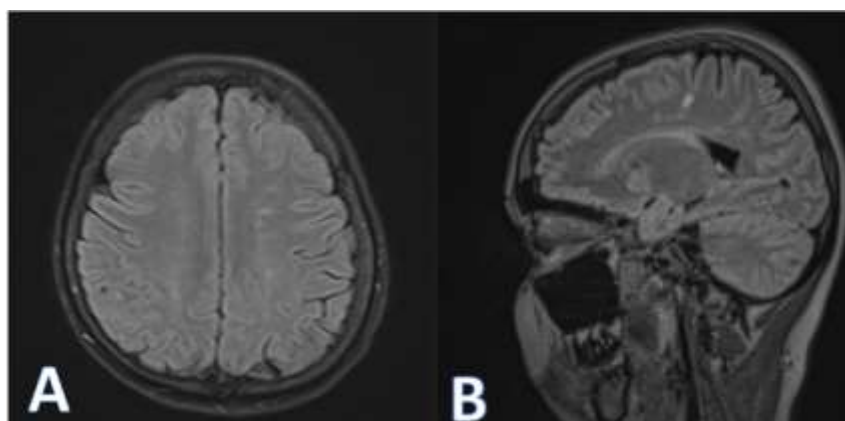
Axial (A) and Sagittal (B) FLAIR depicted high signal peri ventricular lesions with Dawson's finger appearance suggestive of demyelination.
